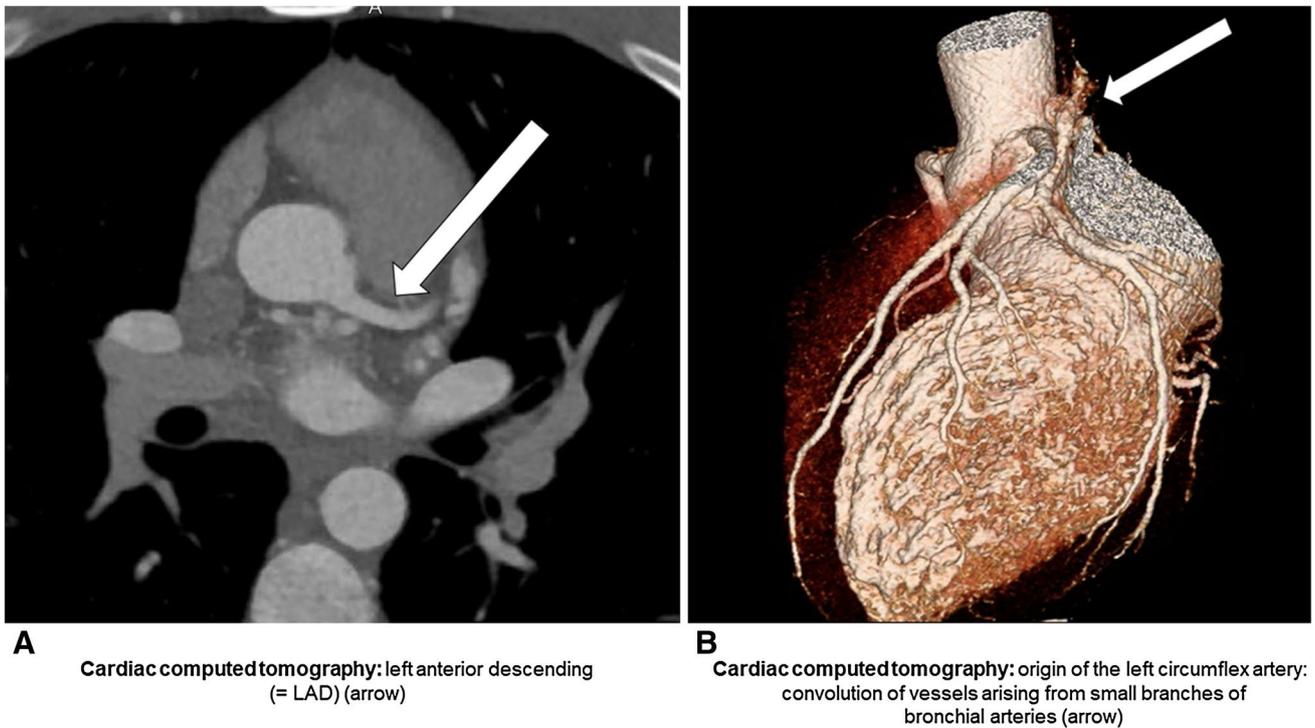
Cardiac computed tomography, showing the coronary anomaly
